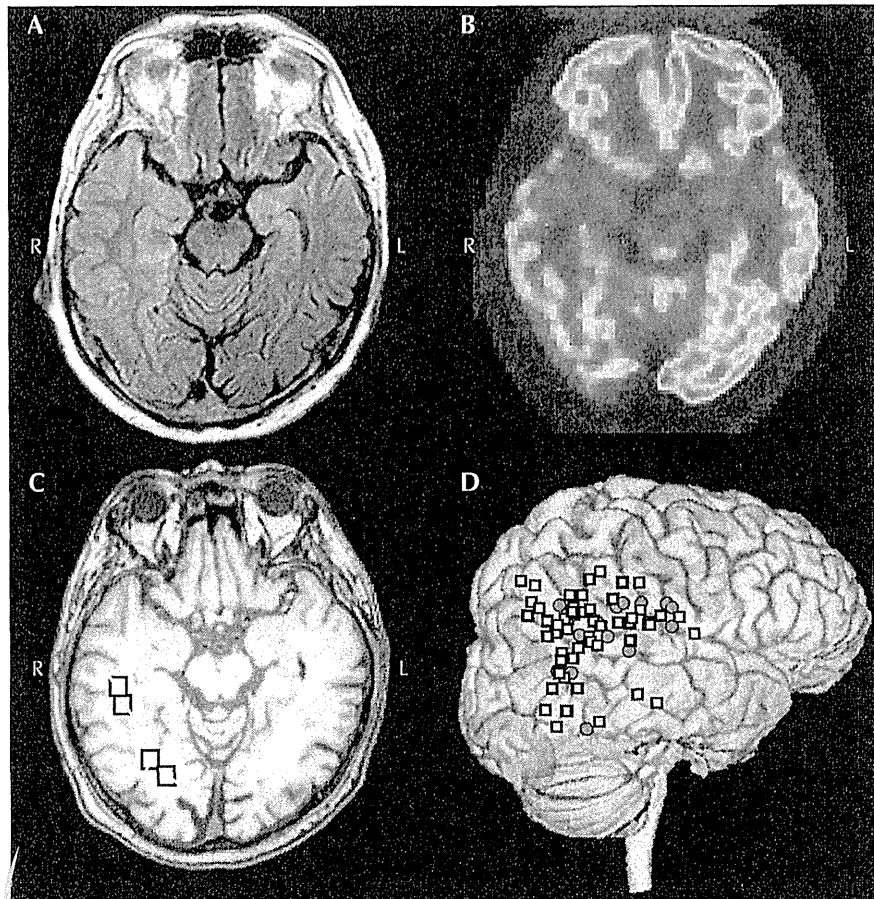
(A) Axial fluid-attenuated inversion recovery MRI of the brain, acquired 12 days after the onset of status epilepticus. Thickening and hyperintensity were observed in the right temporo-parieto-occipital cortex. (B) Fluorodeoxyglucose positron emission tomography and spike dipoles of periodic lateralised epileptiform discharges (PLEDs) estimated by magnetoencephalography, superimposed on T1-weighted MR images obtained upon referral to our hospital (C, D).
